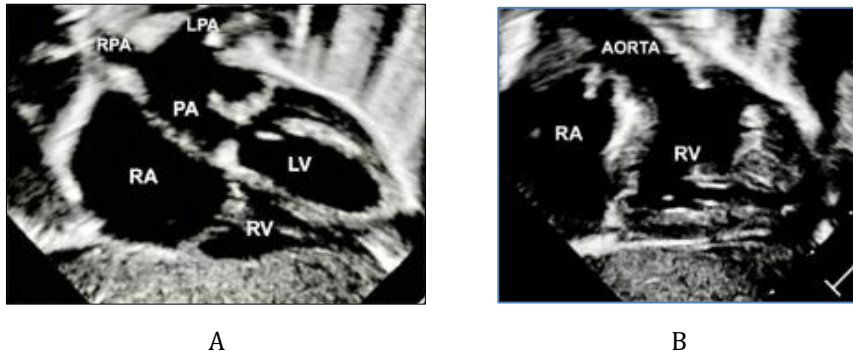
Echocardiography in D-TGA. (A) Five-chamber echocardiographic image shows the PA originating from the LV. LPA=left PA, RPA=right PA. (B) Right ventricular outflow tract echocardiographic image shows the aorta originating from the RV
